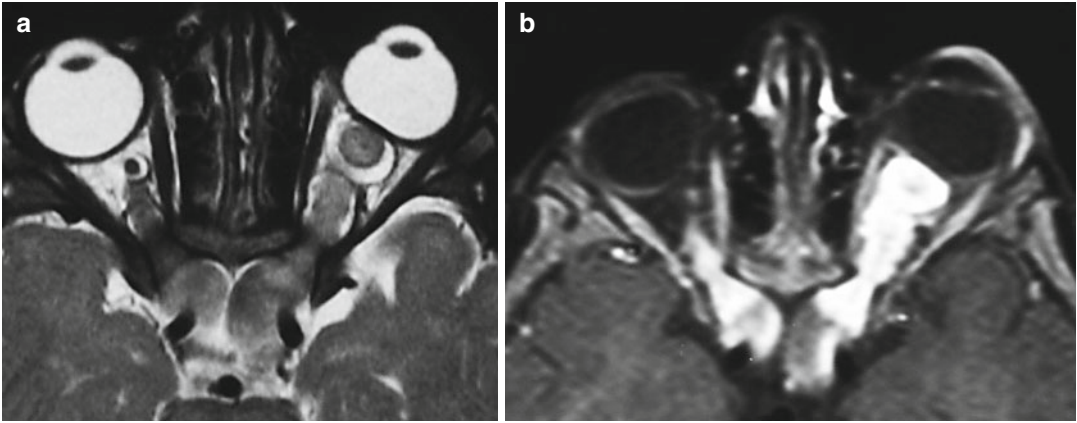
Von Recklinghausen's disease. MR picture of bilateral optic nerve and chiasm glioma on T1- (a) and T2-weighted (b) images
